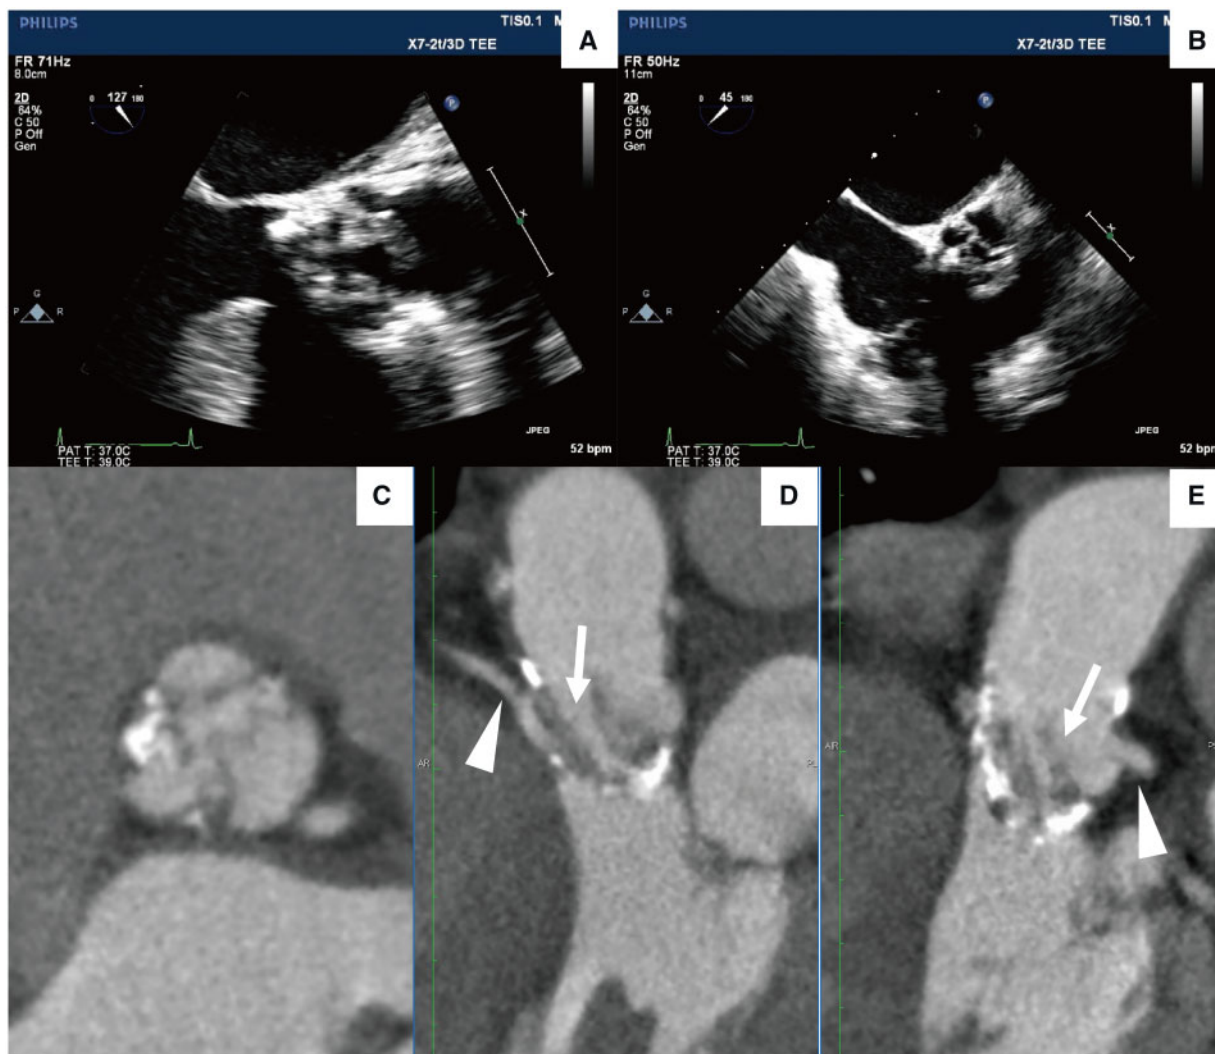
Images of pre-procedural examinations. Left ventricular outflow tract view (A) and short-axis view (B) of transoesophageal echo and short-axis image (C) and long-axis images (D, E) of multidetector computed tomography. All images were in systole. The reconstructed valve leaflets were elongated, thickened, and marginally calcified. Their mobility was decreased, resulting in severe stenosis. The reconstructed right valve leaflet (arrow) was adjacent to the right coronary artery (arrowhead) (D). The reconstructed left coronary leaflet (arrow) was sufficiently long to reach the left coronary artery (arrowhead) (E).
